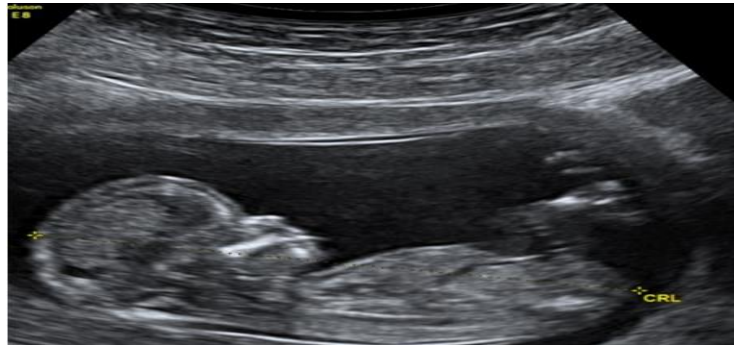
Sonographic evaluation of CRL length ⁽¹⁰⁾
